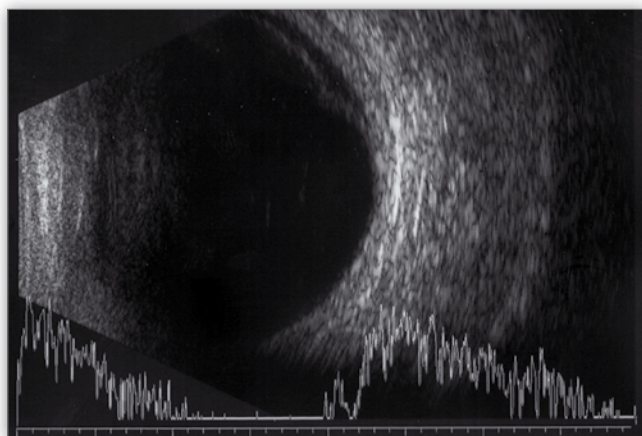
B-scan ultrasound of flat choroidal tumor with secondary retinal detachment prior to the treatment.
